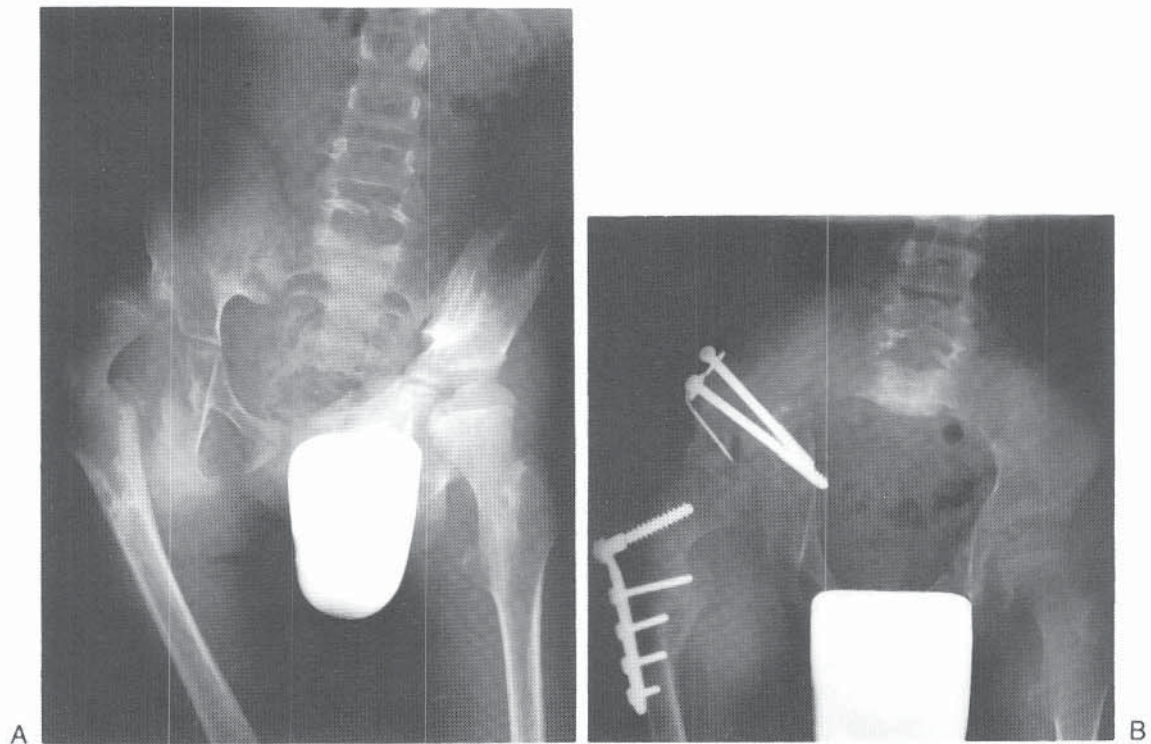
Paralytic dislocation of the right hip in severe spastic cerebral palsy. A, Preoperative radiograph. B, Postoperative radiograph following open reduction with femoral shortening, capsular plication, and Chiari pelvic osteotomy and shelf acetabuloplasty.
